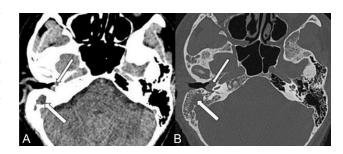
CT of the right temporal bone showing liquid content in the pneumatized right mastoid process and in the antrum. Imaging protocol for showing soft tissue structures (A) and imaging protocol for showing bone structures (B) was used. The right tympanum shows soft tissue content (narrow arrow).
